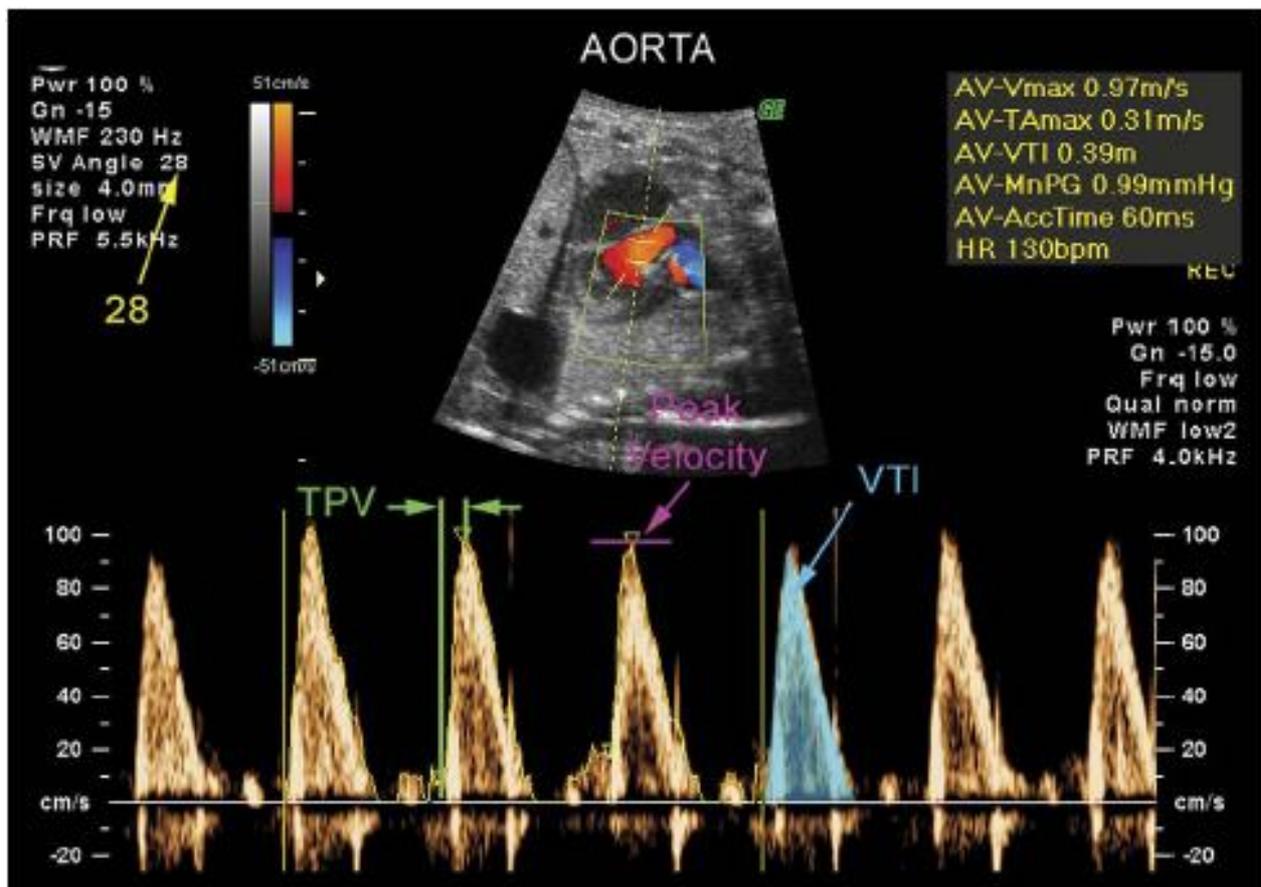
Representative figure for pulsed Doppler recording. Blood flow across the ascended aorta is being sampled. TPV; time to peak velocity or acceleration time and VTI, velocity time integral (a component of cardiac output). Notice the angle correction for aligning the blood flow to the Doppler beam (yellow arrow). Figure from (22).
